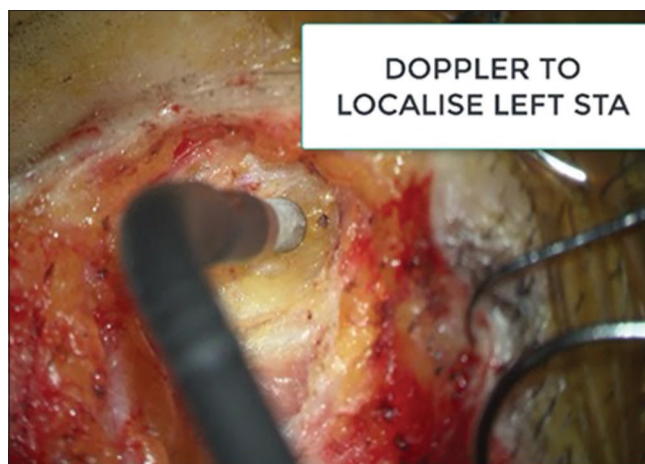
Intraoperative Doppler localization of Donor left superficial temporal artery from the beginning of subcutaneous dissection
